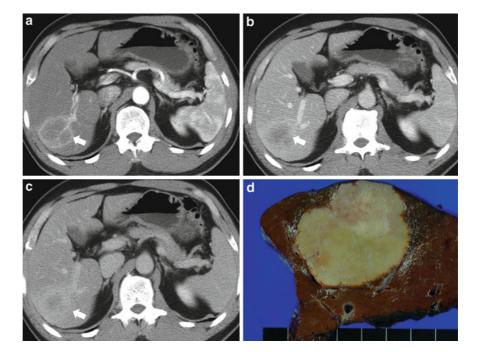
A small intrahepatic cholangiocarcinoma showing arterial enhancement. a Arterial phase CT scan demonstrates a 2 cm, arterially enhancing nodule (*arrow*) in segment 3 of the liver. Note the peripheral intrahepatic ducts are dilated, which
